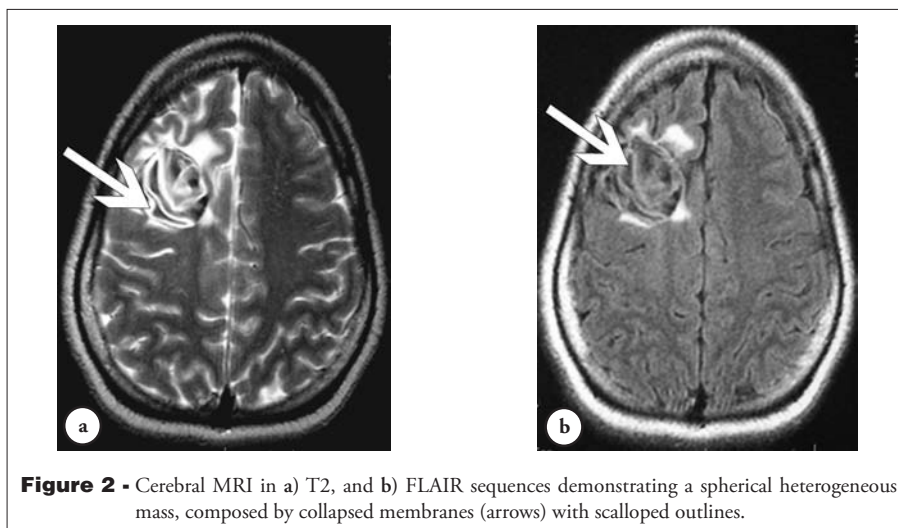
Cerebral MRI in a) T2, and b) FLAIR sequences demonstrating a spherical heterogeneous mass, composed by collapsed membranes (arrows) with scalloped outlines.
